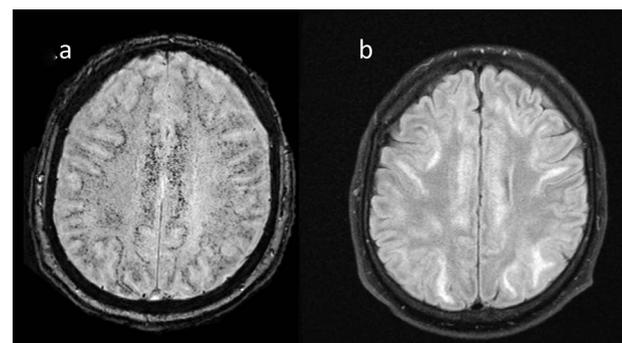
MR SWI demonstrated innumerable foci of hypointensity representing microangiopathy-related microhemorrhages, primarily near the gray/white interface (a). Follow-up MR performed ~1 week after initiation of anti-malarial therapy demonstrated no significant change in cerebral microhemorrhages on SWI images (not shown), with new subcortical signal hyperintensity representing edema on FLAIR images (b).
